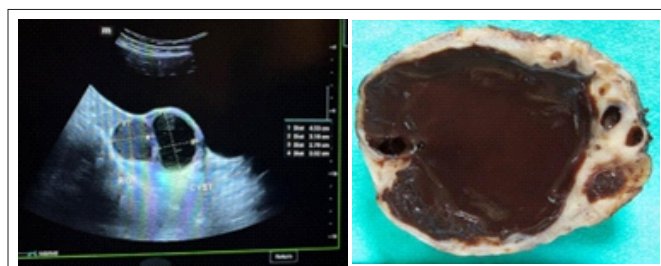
Shows a Ultrasound Image (A) with a well-defined Cystic Lesion in the right Ovary with low-Level Internal Echoes, Suggestive of an Endometriotic Cyst, which was Confirmed upon Gross Examination (B) Showing a Thickened, dark brown outer Surface with Chocolate-Colored Fluid and an Irregular Cyst wall Typical of Endometriosis
